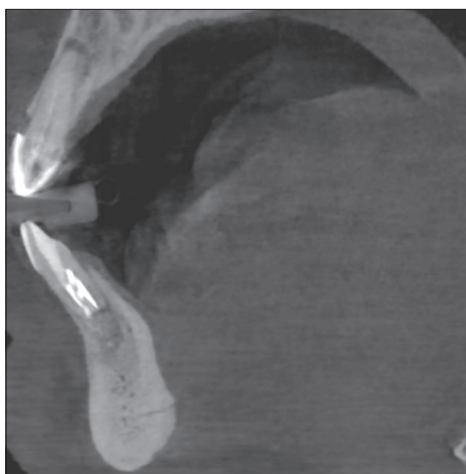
cone-beam computed tomography cross section at 6 months demonstrating the replacement of the Bond Apatite® with new-host bone maintaining the facial contour of the mandible that was affected by the lesion that was removed
